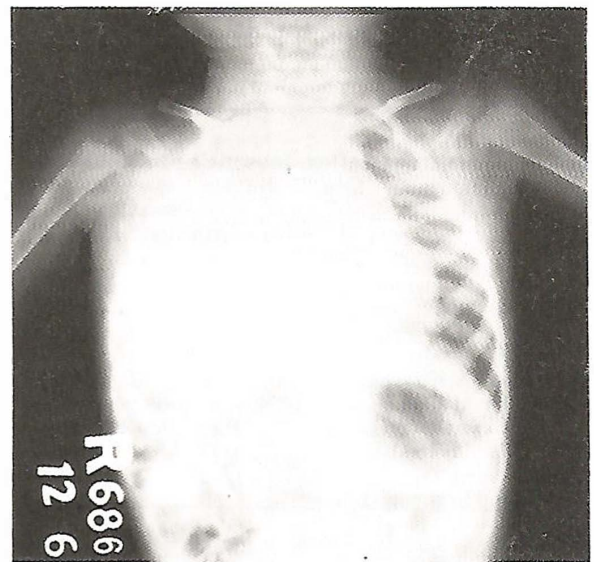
X-ray chest (AP view) showing uniform opacity of right middle and lower zones. Right hemidiaphragm is not visible.
